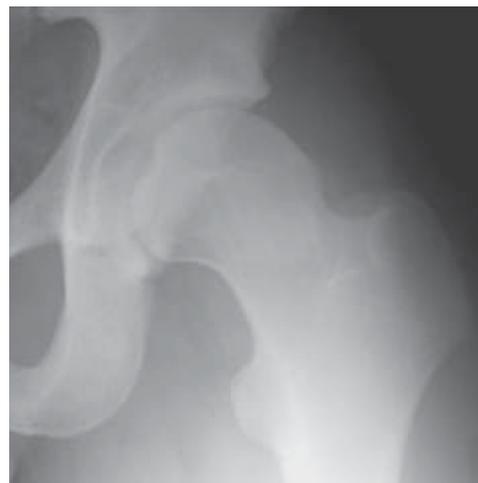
Radiograph of 21-year old wrestler with FAI. Note the non-spherical femoral head. Adapted from Clohisy et al. 2005.
